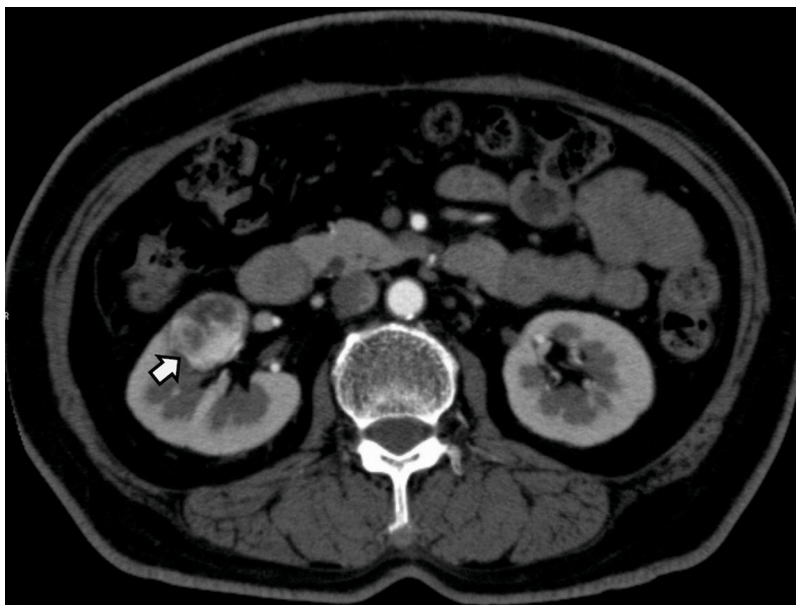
Primary clear cell renal cell carcinoma (RCC) in the right kidney. Dynamic contrast-enhanced computed tomography reveals a well-circumscribed mass in the right kidney. The mass demonstrates heterogeneous strong enhancement in the arterial phase.
